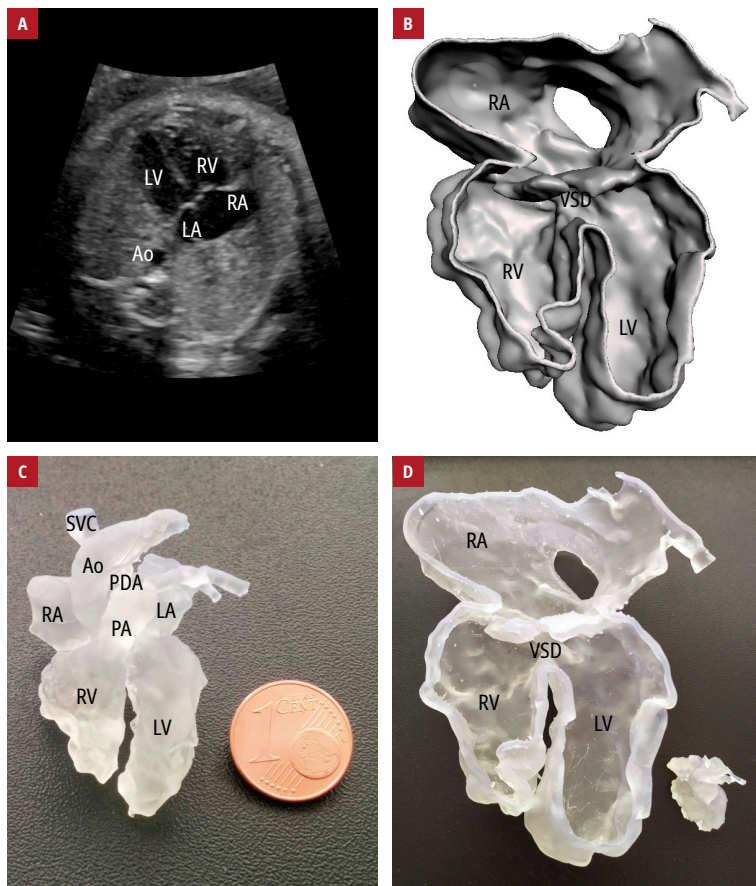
Prenatal imaging and heart models of a male fetus at 27 weeks of gestational age, diagnosed with complete atrioventricular septal defect: A – 2D cardiac ultrasound in a 4-chamber view; B – stereolithography reconstruction obtained from the 4D volume of the heart using spatiotemporal image correlation; C – a 3D printed model of the fetal heart in original size, with clear resin (the 1-cent Euro coin is to show the scale); D – a 5-fold magnified 3D printed model of the heart
